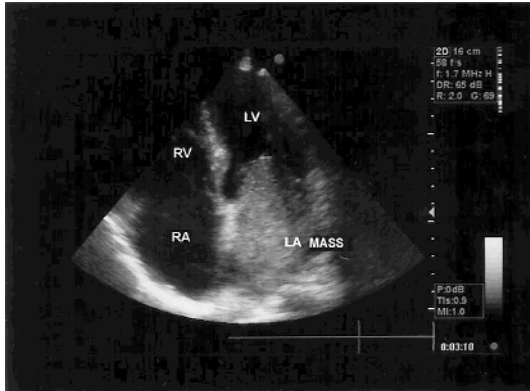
Echocardiography before removal of myxoma
